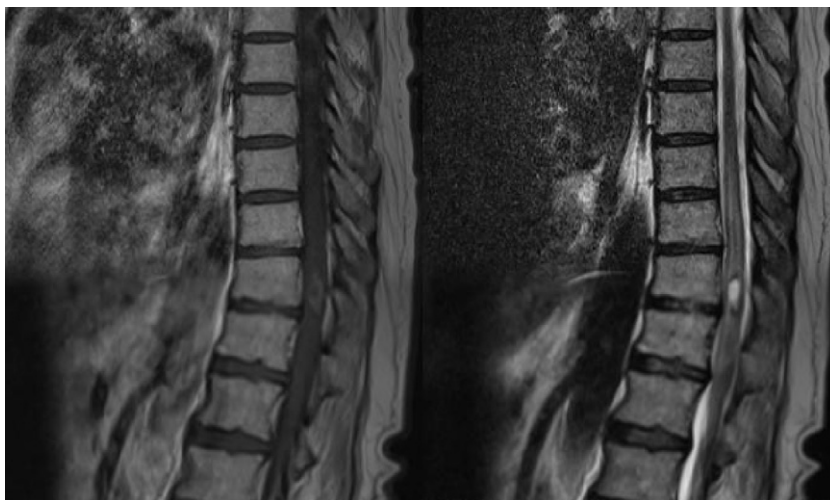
Gadolinium enhanced magnetic resonance imaging showed a nodular lesion in the spine at the level of 11th thoracic vertebrae. This lesion was associated with metastasis.
